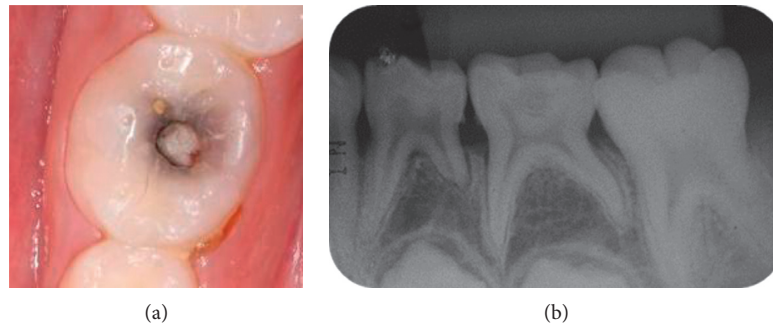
(a) Initial clinical aspect of the primary mandibular left first molar. (b) Initial periapical radiograph of the primary mandibular left first molar. Note the proximity of the carious lesion to the pulp.
